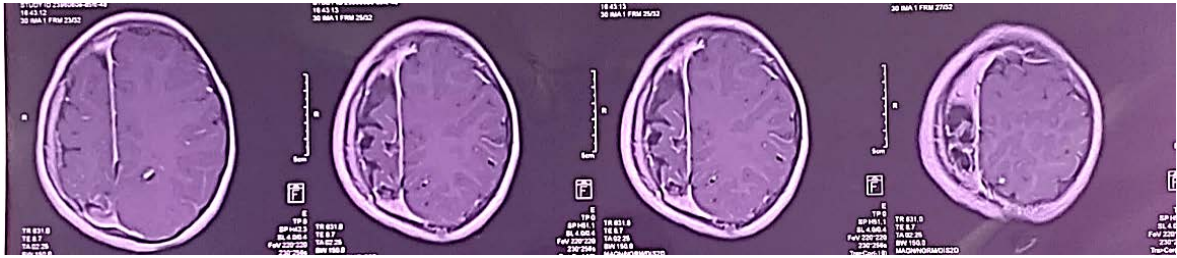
Magnetic Resonance Imaging of the patient's brain showing leptomeningeal angiomas.
